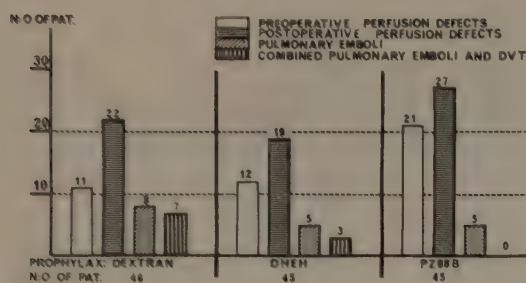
Frequency of scintigraphically diagnosed pulmonary embolism in elective hip surgery.
